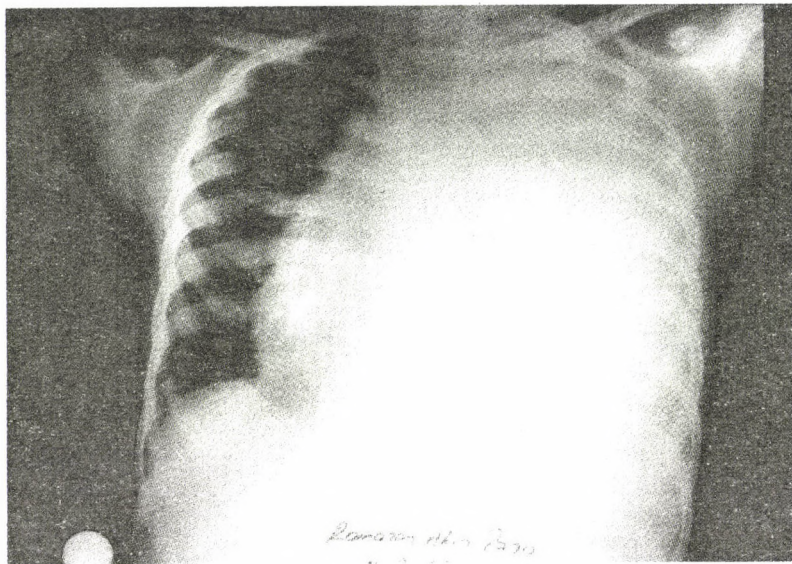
Chest radiograph showed massive left pleural effusion with contralateral mediastinal shift
